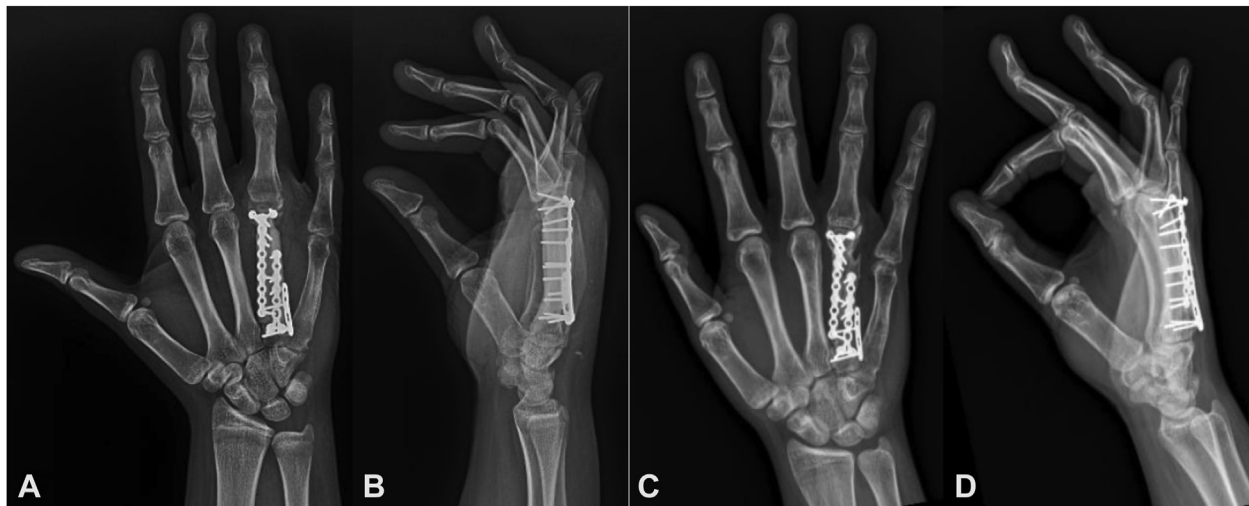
A, B Patient A's immediate posteroanterior and lateral postoperative radiographs demonstrating resection of the calcified mass with fibular strut reconstruction. C, D The 3.5-year postoperative radiographs with stable hardware and congruent ring finger MCP joint with evidence of volar subluxation of the ring finger metacarpal head.
